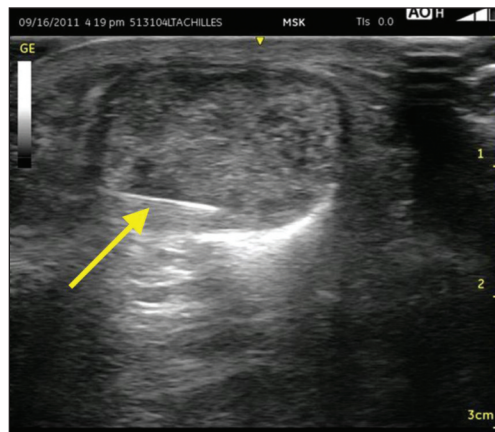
Ultrasound image demonstrates thickening of the Achilles with interstitial tearing and significant tendonopathy. The needle can be seen entering the mid-substance of the tendon (yellow arrow).
